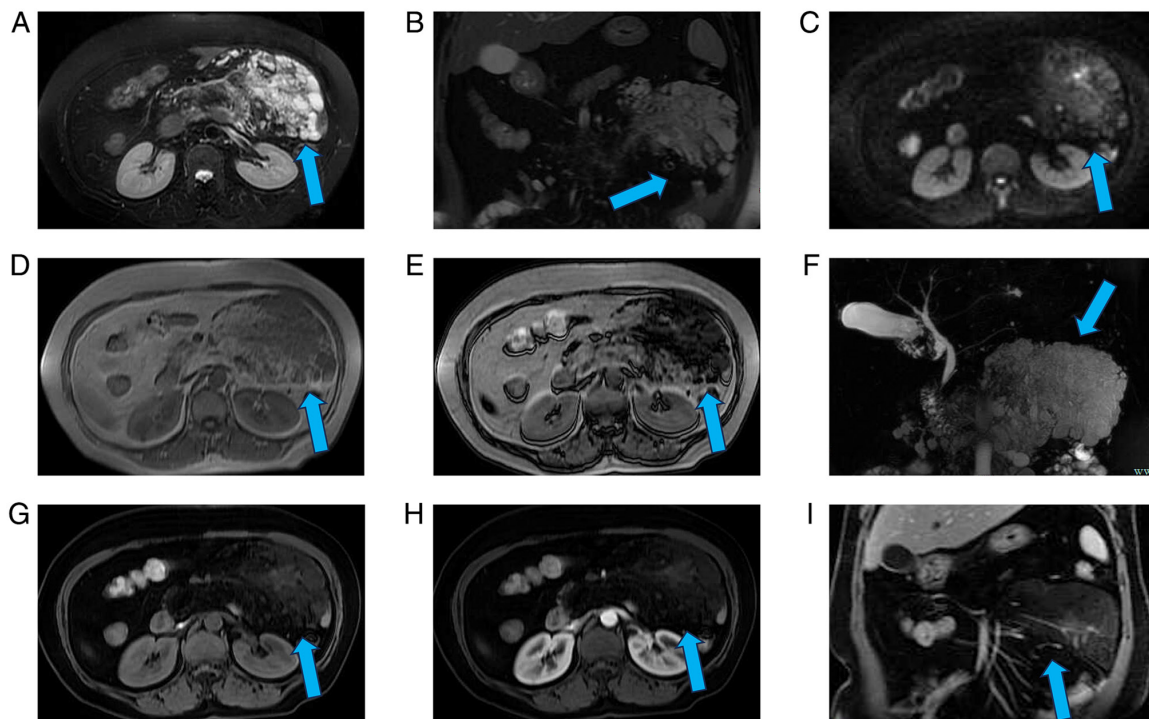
MRI findings of the upper abdomen performed 3 days after admission. (A) Axial T2-weighted fat-suppressed images demonstrating high signal intensity within the lesion (blue arrow). (B) Coronal T2-weighted fat-suppressed image showing the hyperintense appearance of the lesion (blue arrow). (C) DWI showing a small focal area of high signal intensity within the lesion (blue arrow). (D) In-phase T1-weighted image showing relatively homogeneous signal intensity within the lesion (blue arrow). (E) Opposed-phase T1-weighted image demonstrating patchy signal loss within the lesion (blue arrow). (F) MRCP image showing the biliary and pancreatic ductal systems. (G) Non-enhanced axial T1-weighted image demonstrating iso- to slightly hyperintense signal intensity of the lesion relative to the adjacent muscle (blue arrow). (H) Post-contrast axial T1-weighted image showing no notable enhancement of the lesion (blue arrow). (I) Post-contrast coronal T1-weighted image demonstrating persistent absence of notable enhancement within the lesion (blue arrow). MRI, magnetic resonance imaging; DWI, diffusion-weighted imaging; MRCP, magnetic resonance cholangiopancreatography.
